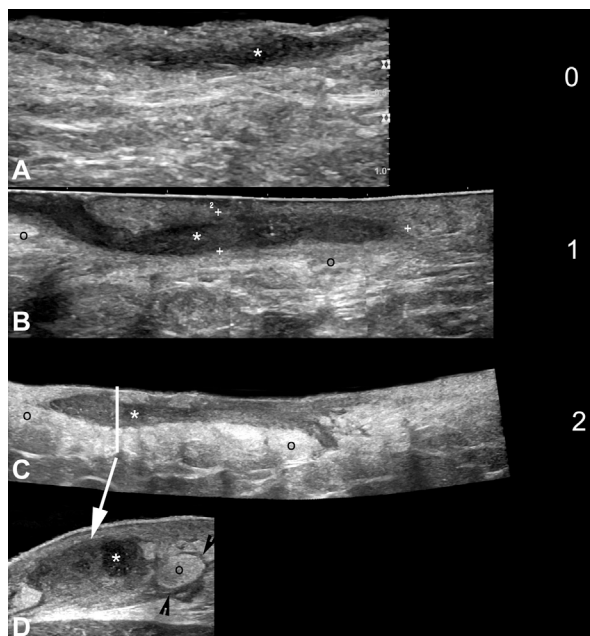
A to D, Hidradenitis suppurativa. Grading of hypodermal edema (o) surrounding HS fistulous tracts. Grey scale ultrasound; extended field of view of the long axis of fistulae (*). In D, a cross-sectional view (transverse axis) of the fistulous tract (*) with edema (o) grade 2 is shown. Notice the hypoechoic fluid (black arrowheads) in between the fatty lobules in D. *, Center; +, markers of the borders of the fistulous tract.
